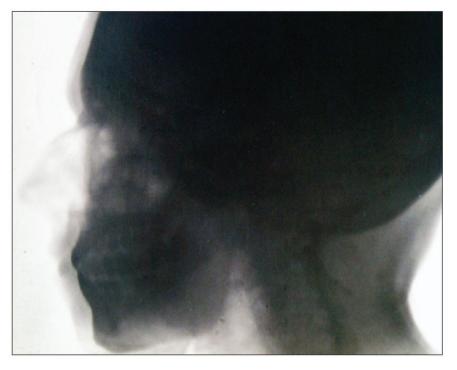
Photograph of the skull taken by Tesla, 1896.Figure 4 An X-ray picture taken by Nikola Tesla, 1986
